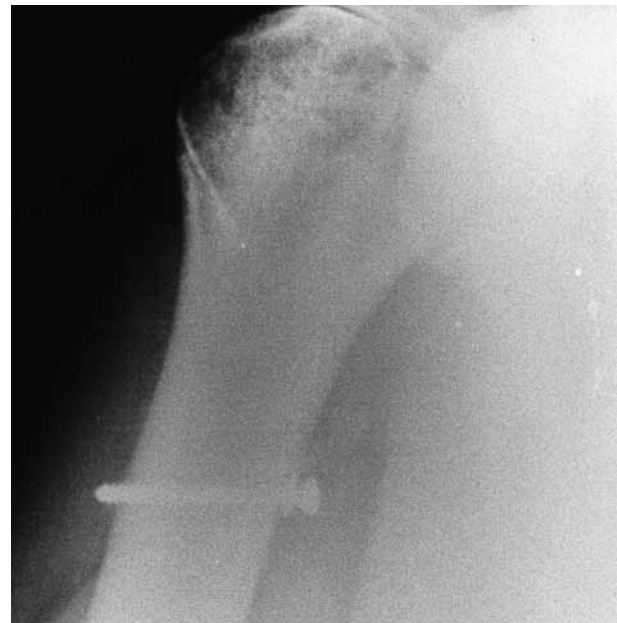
Postoperative AP radiograph, showing humeral attachment of the autologous graft.
